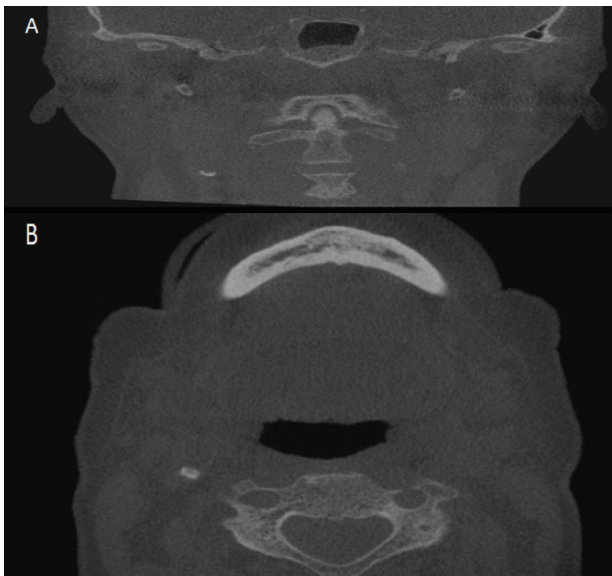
Coronal section (A) and axial section (B) of the cone beam computed tomography showing the calcified carotid artery atheroma.
